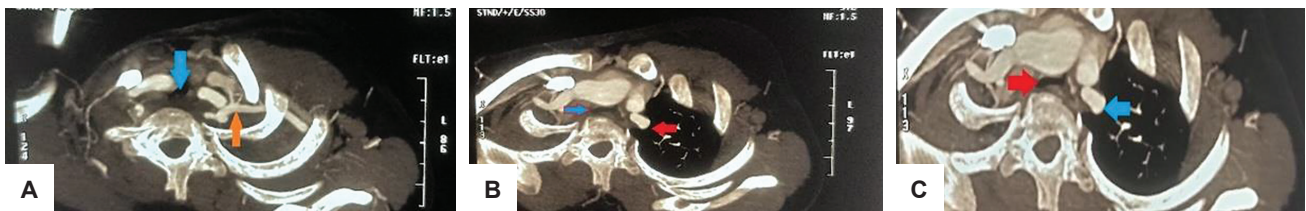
Cardiac MRI showing cardiovascular abnormalities in subjects with Turner syndrome. (A) Dilated subclavian artery (blue arrow) and elongated transverse aortic arch (orange arrow); (B) Coarctation of aorta (blue arrow) and dilated subclavian artery (red arrow); (C) Coarctation of aorta (red arrow) and dilated subclavian artery (blue arrow).
